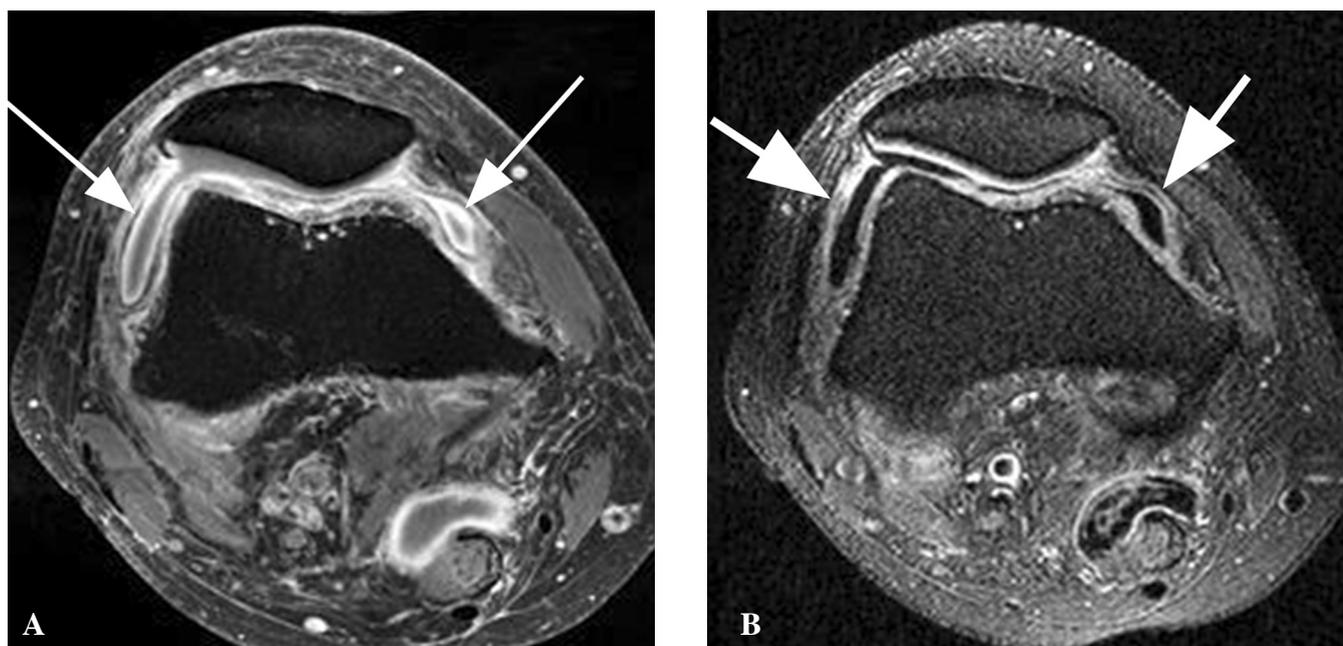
7T MRI of synovitis in knee OA.
